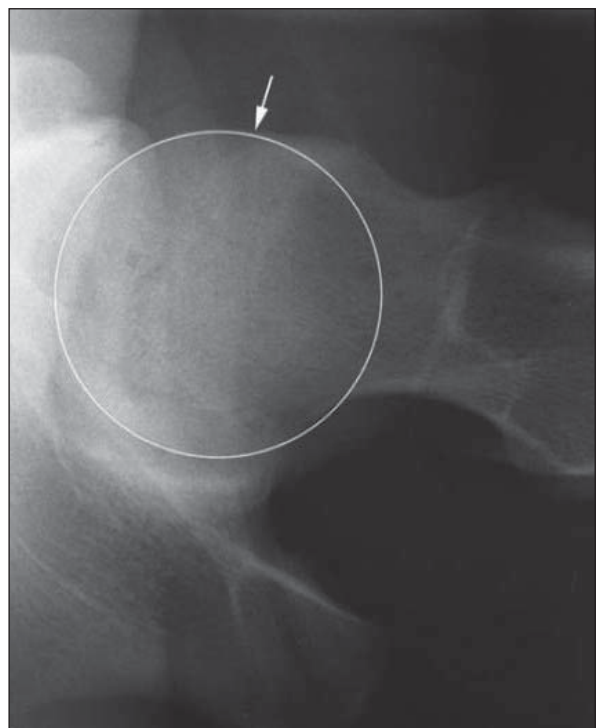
Antero-posterior hip radiograph demonstrating a cam lesion.
